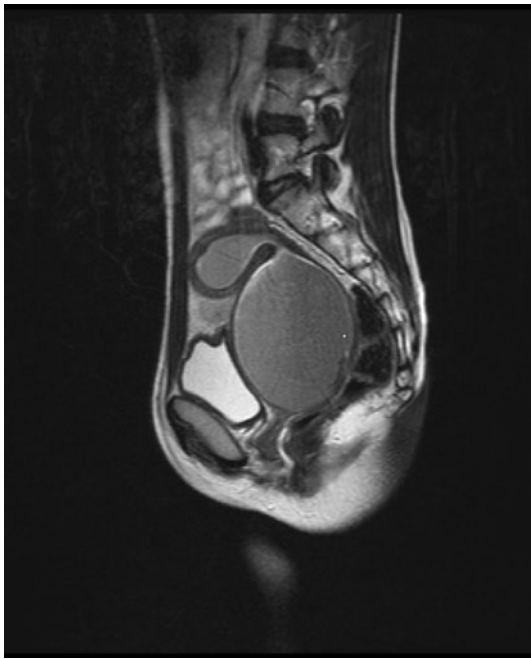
MRI findings in a patient with transverse vaginal septum
